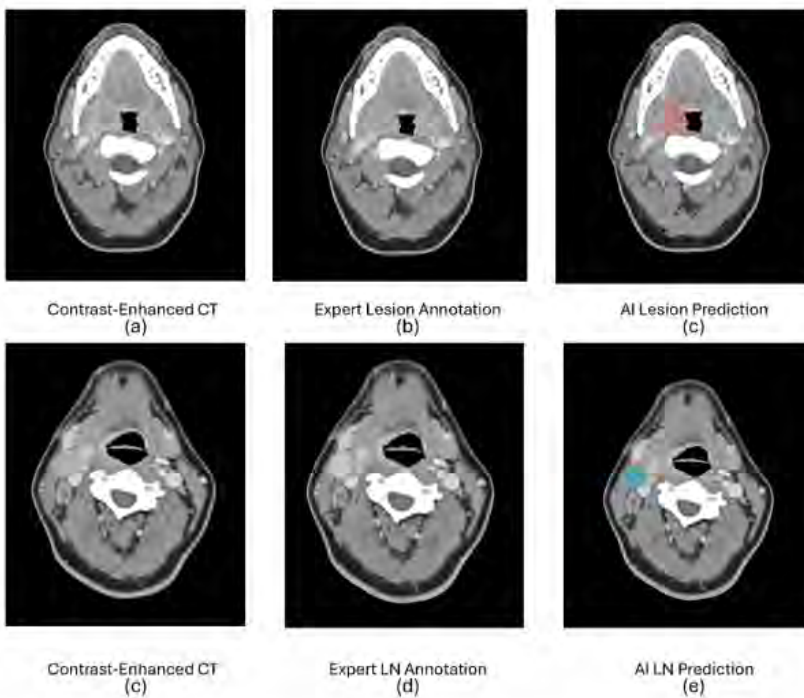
External Test Set Model Performance. (a) Shows the original contrast enhanced CT scan of the patient. (b) Shows the Expert's annotation of a lesion in green. (c) Shows the predicted location of the lesion identified by the model in red. Lesion DICE was 0.90. (d) Shows the Expert's annotation of an enlarged LN in yellow. (e) Shows the model's prediction of where an enlarged LN is in blue. LN DICE was 0.82.
